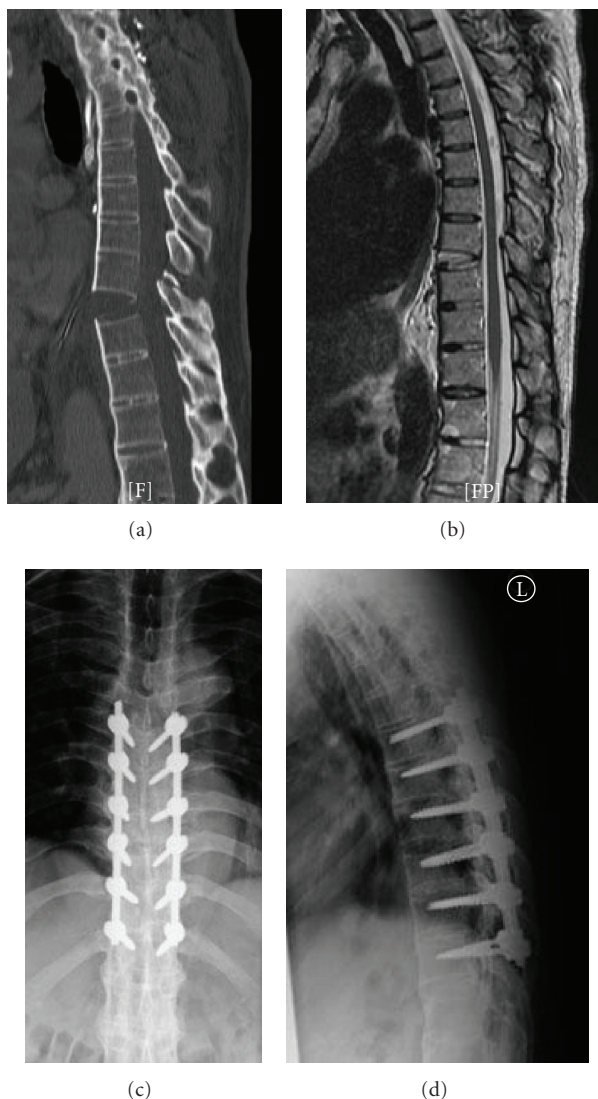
Sagittal computed tomography (a) and magnetic resonance image (b) of a 40-year-old male with an extension injury through the T9-10 disc extending posteriorly into the T9 posterior elements. Postoperative anteroposterior (c) and lateral (d) radiographs after realignment and posterior instrumented fusion.
